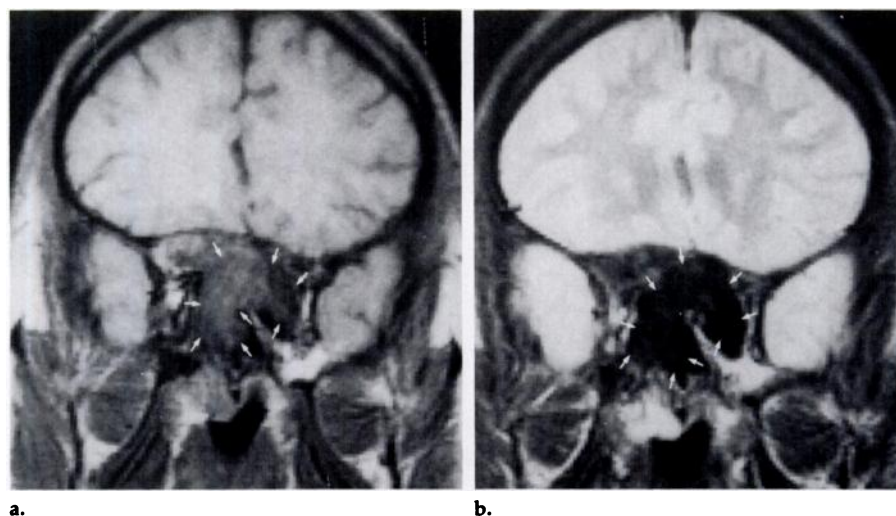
Sphenoid fungal sinusitis. (a) Coronal T1-weighted MR image through the sphenoid sinus reveals hypointense signal from a mass (arrows). (b) T2-weighted image shows an even lower intensity signal (arrows) than on the T1-weighted image.
